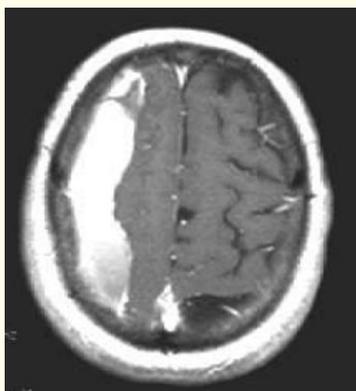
Magnetic resonance imaging (MRI) for Isodense subdural hematoma.
